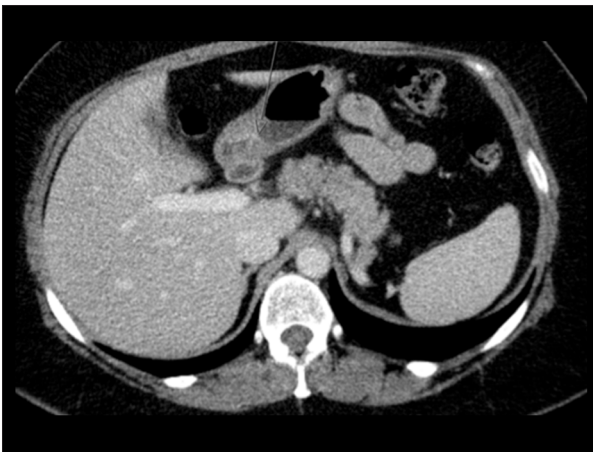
CT scan showing asymmetric appearance of the stomach and pylorus with nodularity of the mucosa and thickening of the posterior wall (arrow).
